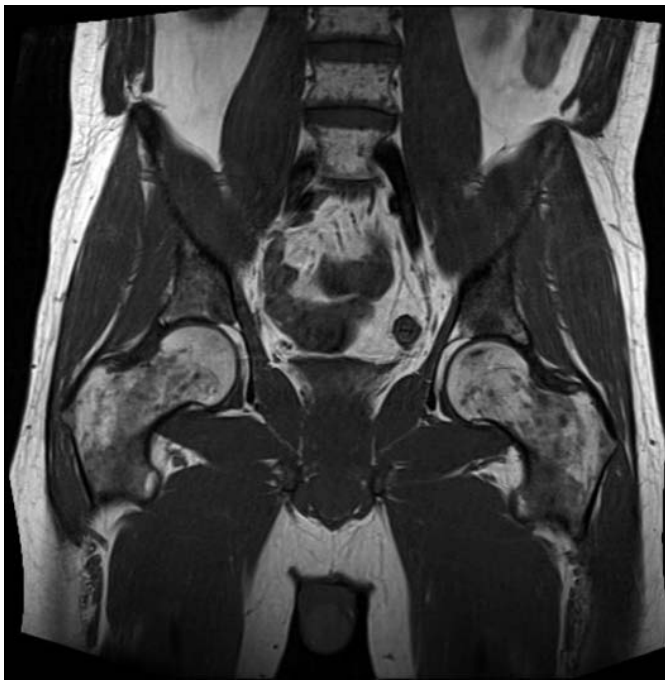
T1-weighted MRI scan with multiple mottled signal changes in the whole skeleton of the pelvis and pathological enhancement of the contrast medium.
